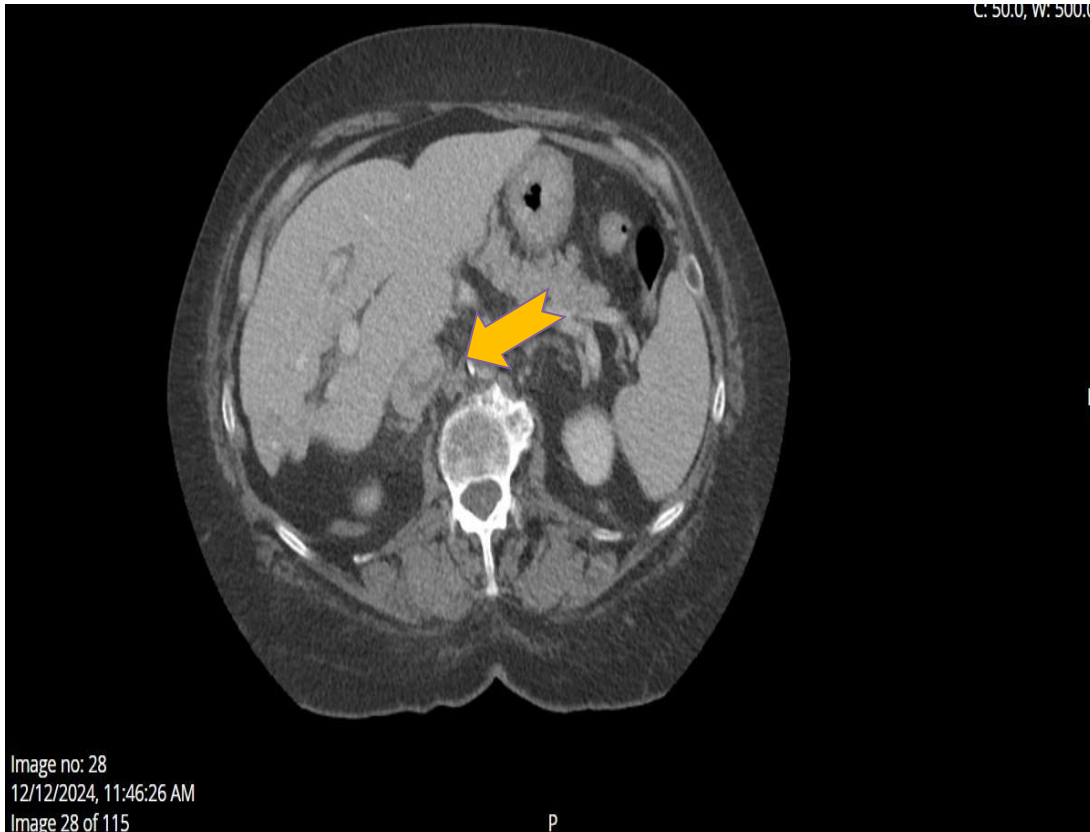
CT Scan Abdomen/Pelvis with contrast: This is a axial view of the abdomen showing a non-occlusive thrombus in the Inferior Vena Cava (IVC) [Yellow arrow]. Cirrhotic changes in the liver are described.
